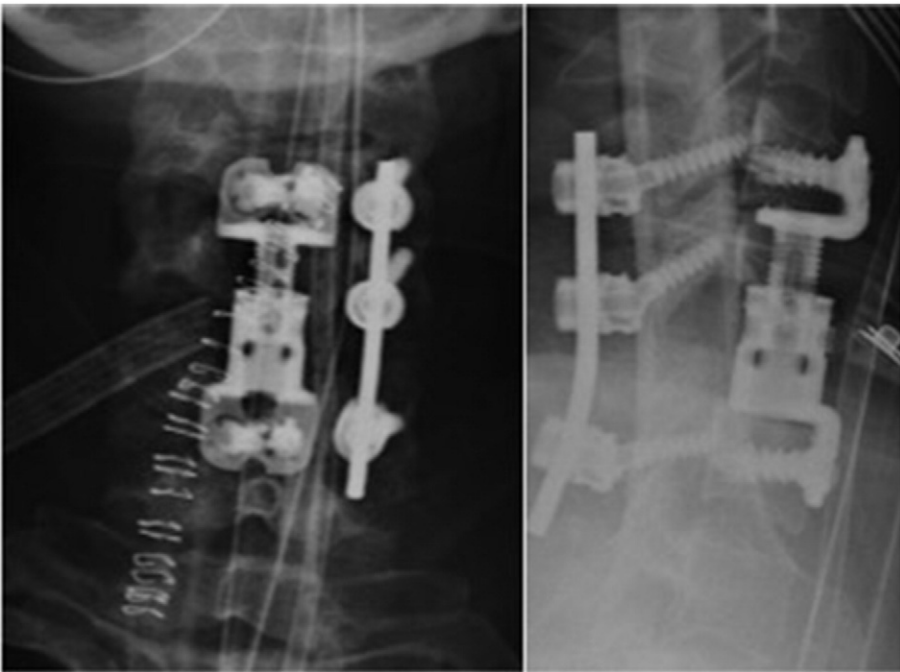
Postoperative day 1 cervical x-ray after the patient underwent C5 corpectomy and the placement of the expandable cage with a built-in anterior cervical plating system. Unilateral lateral mass screws were placed on the left side. The expandable cage is well opposed to the endplates.
